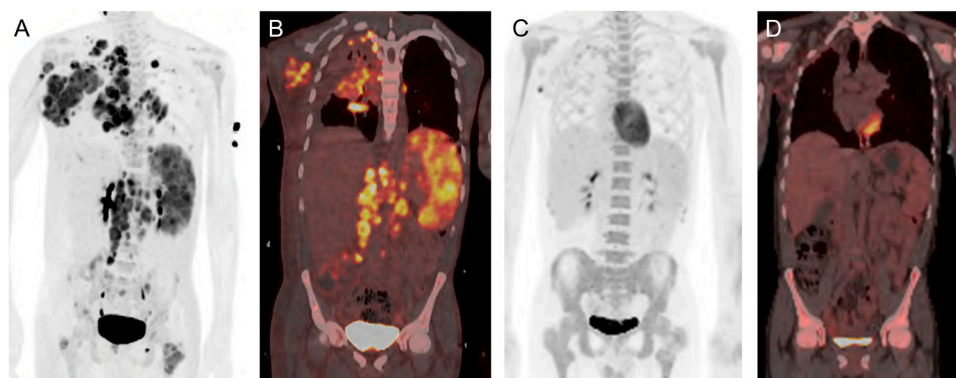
FDG PET scan in July 2023 demonstrated tracer uptake in the cervical, supraclavicular, thoracic, abdominal, and pelvic lymph nodes as well as the spleen (A). Fused PET/CT showed FDG uptake bilaterally in the retroperitoneal lymph nodes and spleen (B). FDG PET and fused PET/CT scans in November 2023 with resolution of multifocal FDG avid lymphadenopathy and FDG avid splenic, osseous, and pulmonary/pleural lesions with a persistent FDG avid right axillary lymph node, suggestive of partial metabolic response (C-D).
